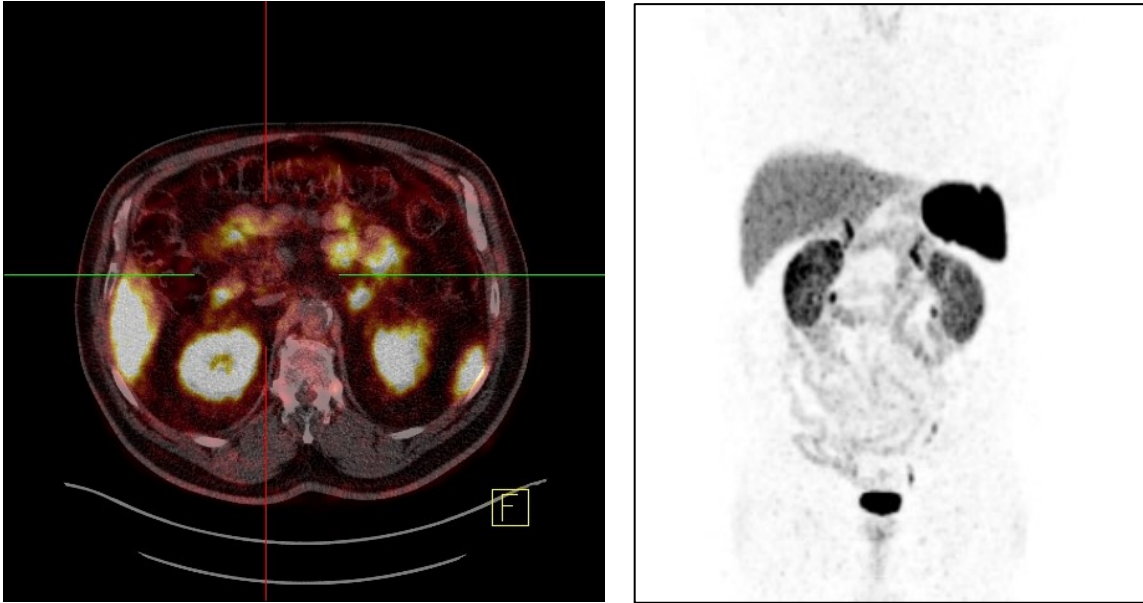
Non-suspicious finding with SUV_{max} 13.06 measured in the pancreas
